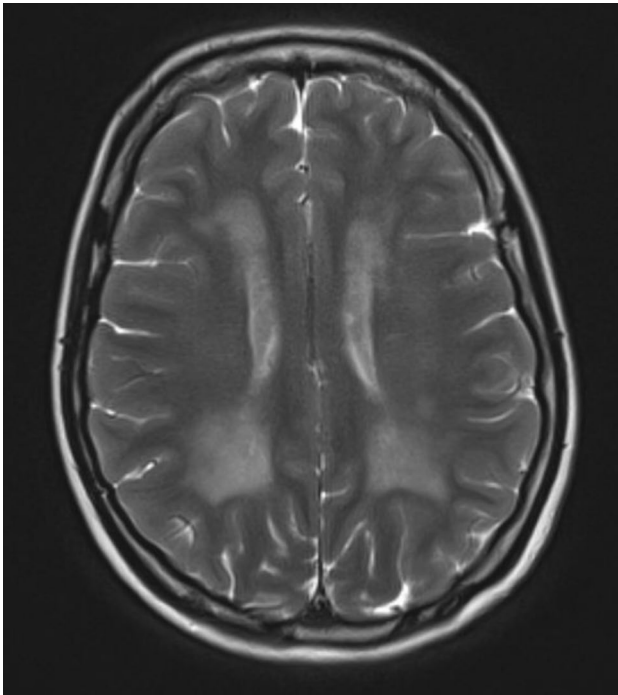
T2-weighted MRI head -symmetrical confluent T2 hyperintensities in the periventricular, deep and subcortical white matter in fronto-parietal regions.
